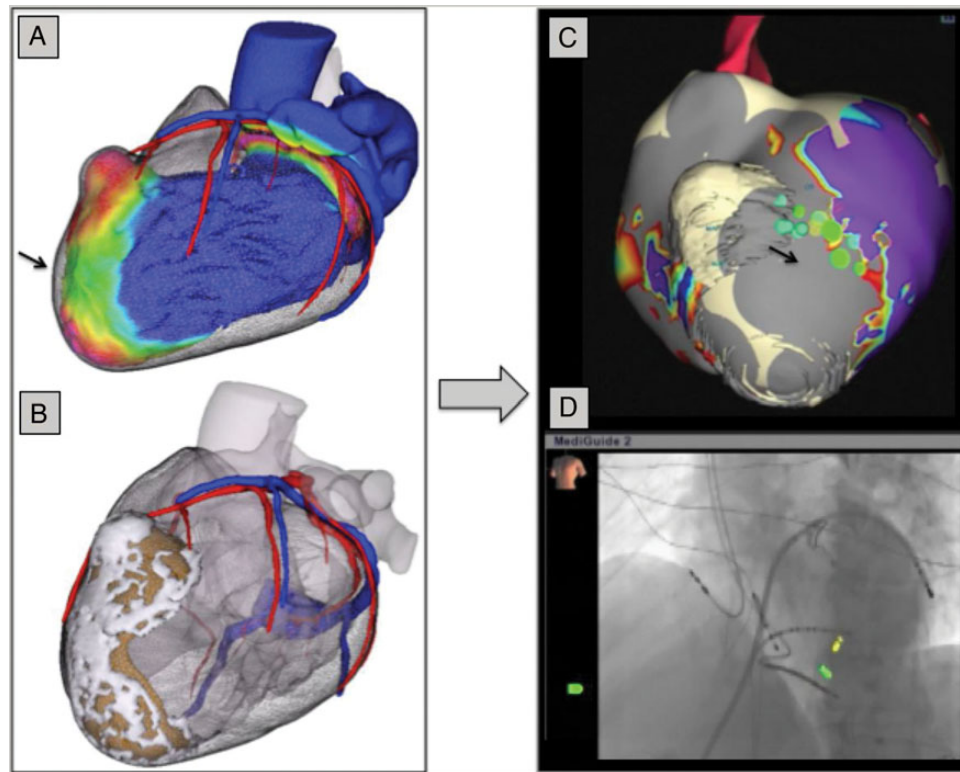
Patient 3 with ischaemic cardiomyopathy and an endocardial thrombus (lateral view). (A) Multidetector computed tomography color-coded wall thickness map showing an anterior left ventricular aneurysm with wall thinning (blue is normal thickness and red is <3 mm with intermediate thickness in green). An epicardial isthmus can be seen (black arrow). (B) Three-dimensional mesh (derived from MDCT) made using Music[®] software with coronary artery system in red, coronary venous system in blue, scar with calcification in white, and large mural thrombus in brown. (C) Epicardial bipolar voltage map with merged image and EAM image, using the EnSite[™] Velocity[™] system (St Jude Medical). Purple is normal voltage >1.5 mV, green is borderzone >0.5 to <1.5 mV, and grey is dense scar <0.5 mV. Green LAVA dots are manually tagged and seen besides the aneurysm inside the anatomical isthmus (black arrow). (D) Fluoroscopic anteroposterior (AP) image using the MediGuide[™] system. Anterior epicardial access, using a steerable sheath (Agilis[™], St Jude Medical). Magnetic sensors of MediGuide-compatible catheters (both St Jude Medical) show the tip of the ablation catheter (Saphire[™] BLU[™]) in yellow and a decapolar catheter (LiveWire[™]) in green. Atrial and ventricular leads of intracardiac defibrillator are visible.
